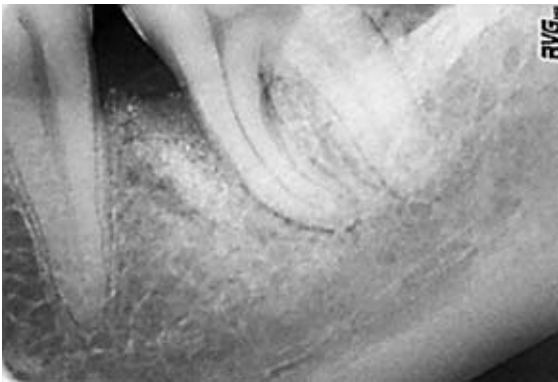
Radiograph of tooth 36, 6 months after treatment. Defect filling can be seen.
